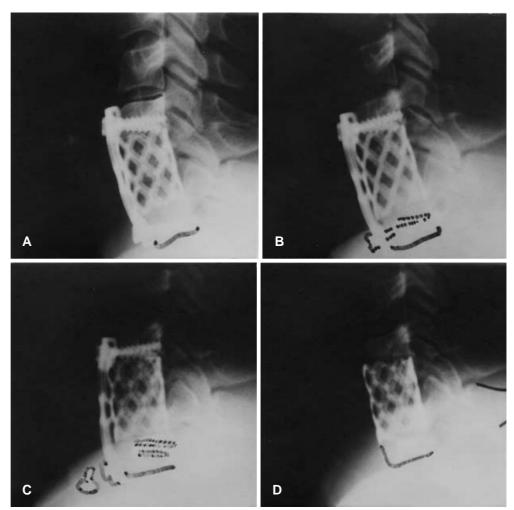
A Preoperative magnetic resonance imaging showing cervical spondylosis with multiple level stenosis. B Postoperative lateral radiograph of the same patient 1 year after corpectomy of the 5th cervical vertebra and intersomatic fusion at the C3/4 disc level Fig.3 A Postoperative lateral radiograph after single-level anterior corpectomy of the 6th cervical vertebra and anterior plating. B Lateral radiograph 6 months after the operation showing sinking-in of the cage and breakage of the caudal screws. C Lateral radiograph of the same patient 1 year after surgery showing migration of the broken screws. D Lateral radiograph after removal of the plate and screws. Complete fusion was evident intraoperatively
